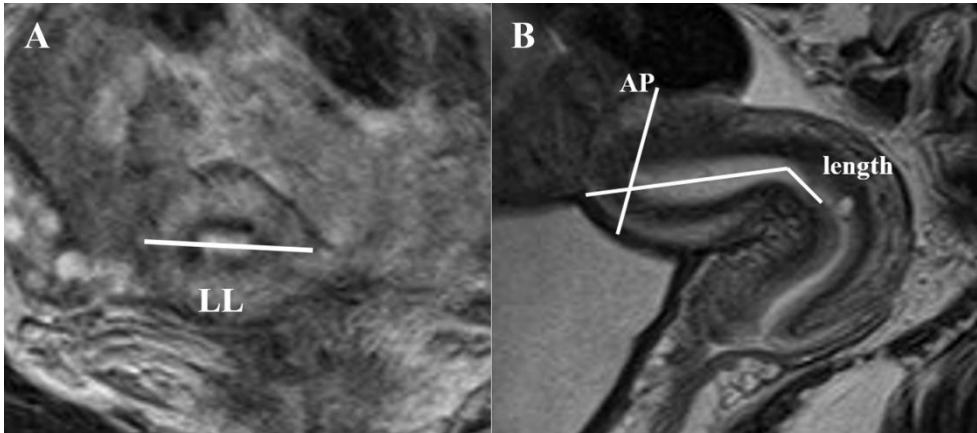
Dimensions measurements of the corpus uteri on sagittal and transversal magnetic resonance imaging (MRI). The sagittal T2-weighted MR image (B) was used to measure the antero-posterior (AP) uterine size and the length of the uterus, and the transversal T2 weighted image (A) was used to measure the latero-lateral (LL) uterine size.
